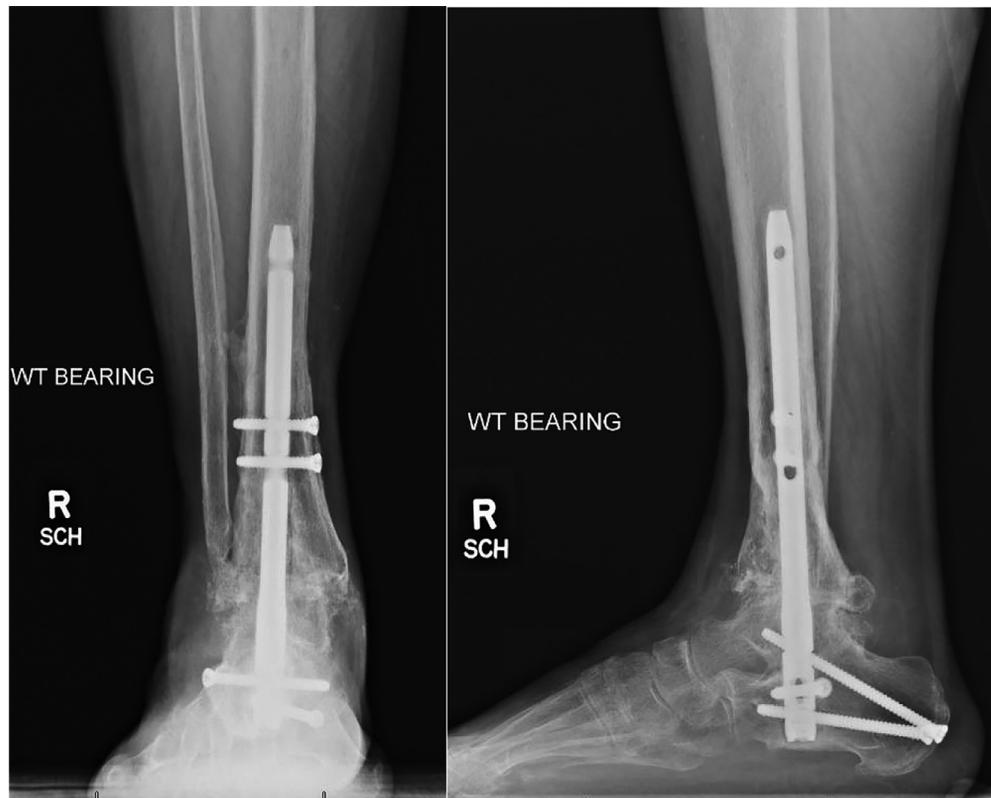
Postoperative anteroposterior and lateral radiographs showing stable correction of the patient's ankle with maintenance of a plantigrade foot.
